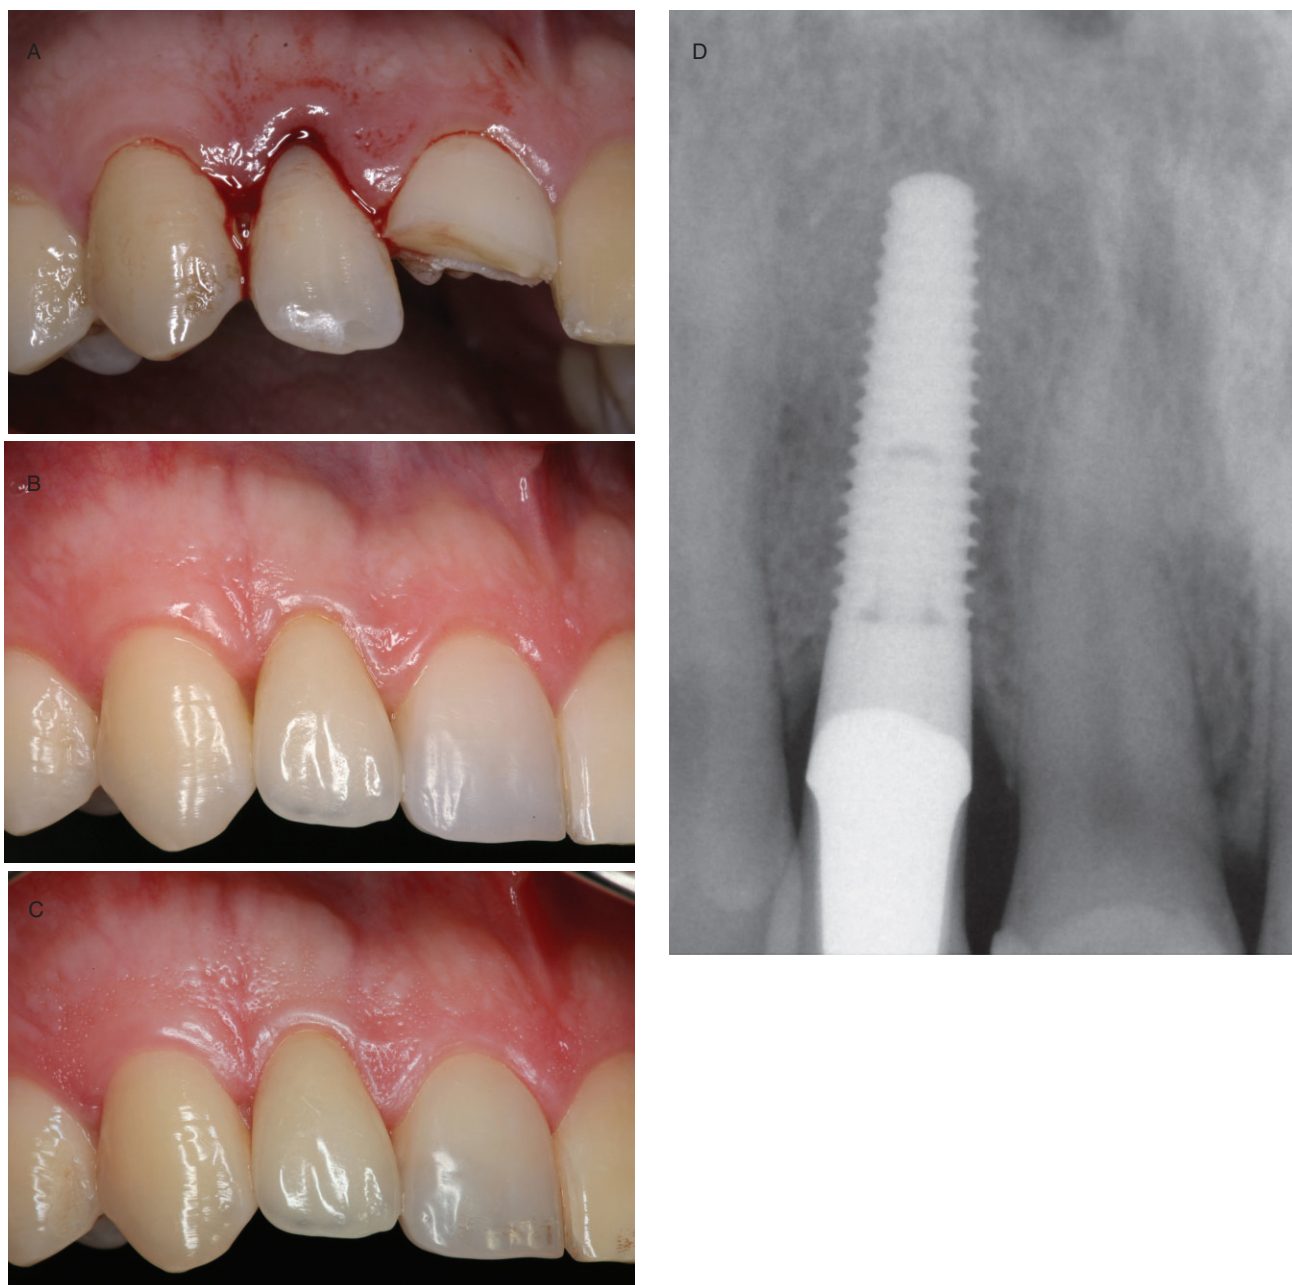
Single-tooth replacement in the maxilla. (A) Initial clinical aspect of the right lateral incisor and the marginal tissues after trauma of the incisors. The lateral incisor was fractured horizontally and was extracted. (B) Clinical aspect 24 months after extraction, simultaneous implant placement, and immediate provisionalization and loading. The PES rating was 12. (C) Clinical aspect 77 months after implant placement reveals improvement of the height of the marginal contour and the distal papilla. The PES rating is 13. (D) Intraoral radiograph 77 months after surgery. Consolidation of the radiolucency and a favorable marginal bone level at about 2 mm above the first thread are noticed. (PES = pink esthetic score.)
